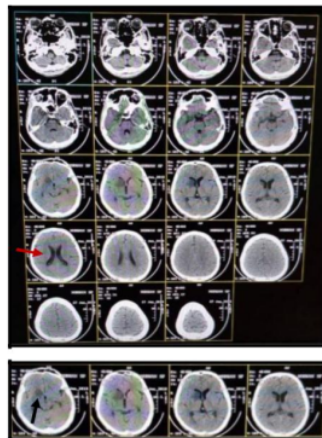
Non-contrast Head Computed Tomography scan showing multiple hypodense lesions of the right caudate nucleus, right internal capsule, right lentiform nucleus, and right temporal lobe (black arrow) with ventriculomegaly (red arrow), suspected cerebrital DD / Infarction.
